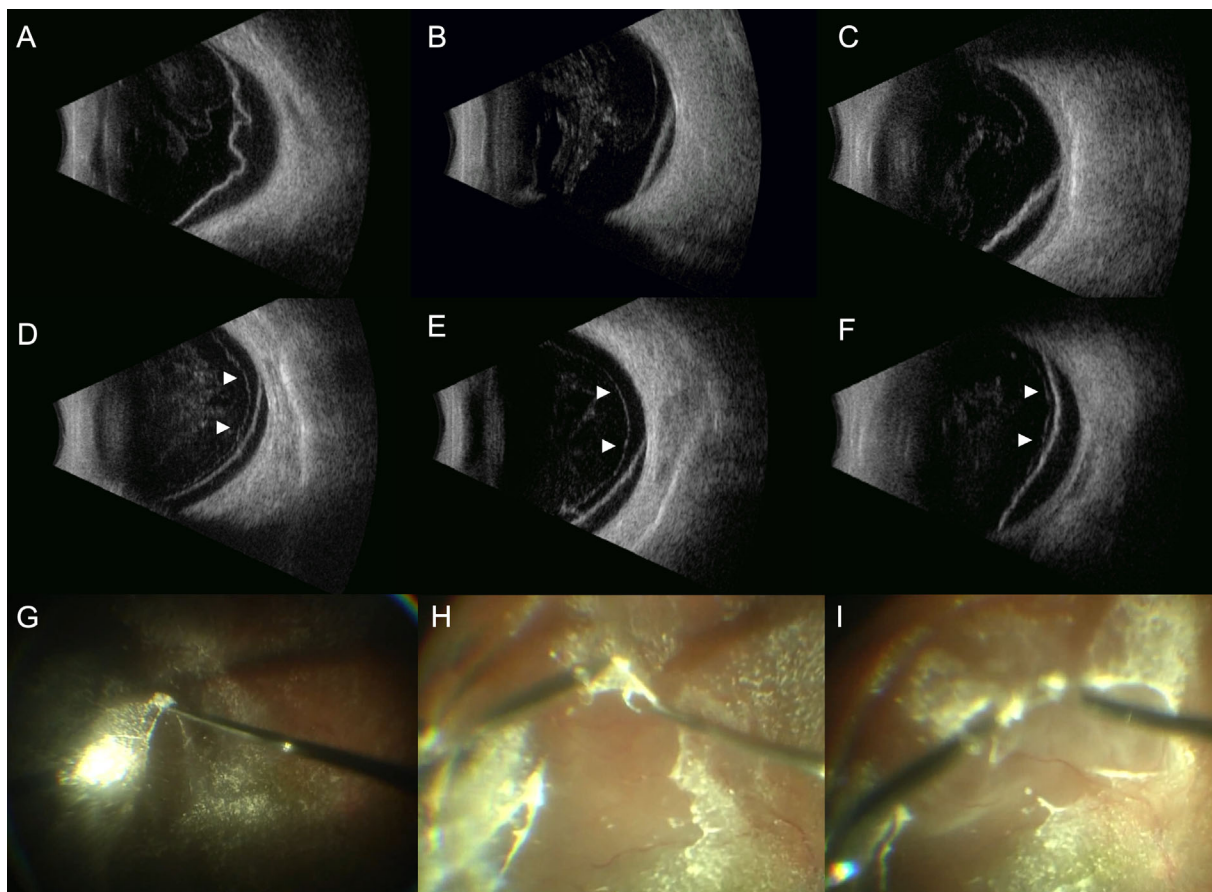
Transverse B-scan ultrasound images that show the relationship between the vitreous cortex and the retina pre-operatively and color pictures showing the corresponding intra-operative findings. (A–C) The vitreous cortex is partially attached A and completely detached from the detached retina B and C, respectively, and appears wavy, not following the contour of the adjacent retina. (D, E, F) Examples of the “lining sign”: the vitreous cortex is partially detached D and F or completely detached E from the retina and runs parallel to the detached and attached retina. (G, H, I) Intra-operative evidence of peripheral vitreous cortex remnants (pVCRs) in the eyes showed in D, E, and F with pre-operative evidence of the “lining sign.” The pVCRs are scraped away from the retinal surface with a flexible nitinol loop and with forceps.
